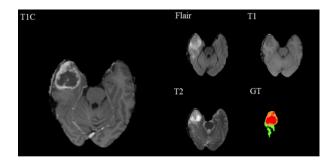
T1, T1C, FLAIR, T2, GT images
